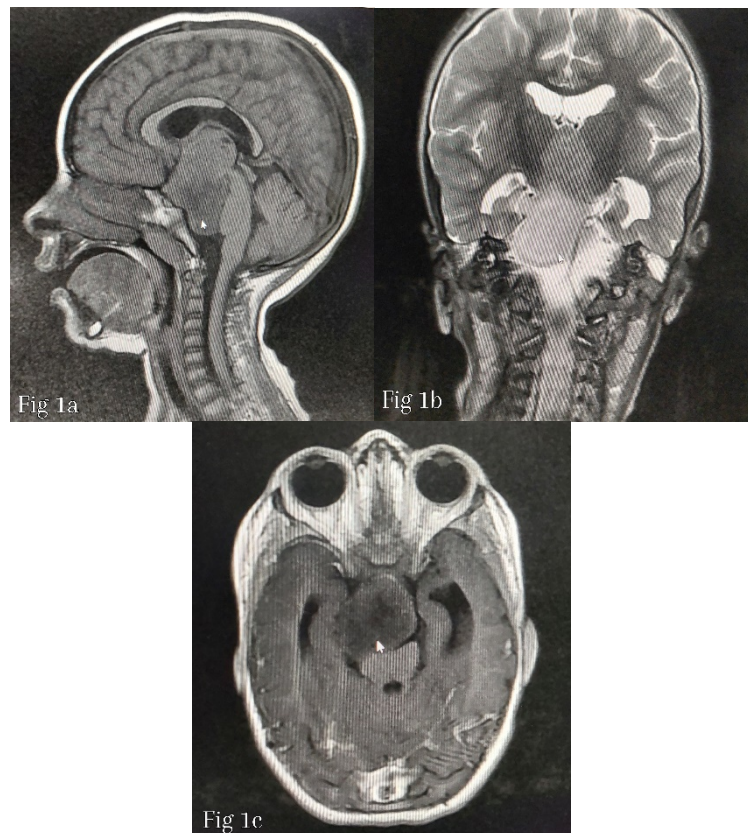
MRI images showing a giant lesion iso hypointense to the gray matter on T1 weighted (a) hyperintense on T2 weighted (b) with no obvious contrast enhancement (c).
